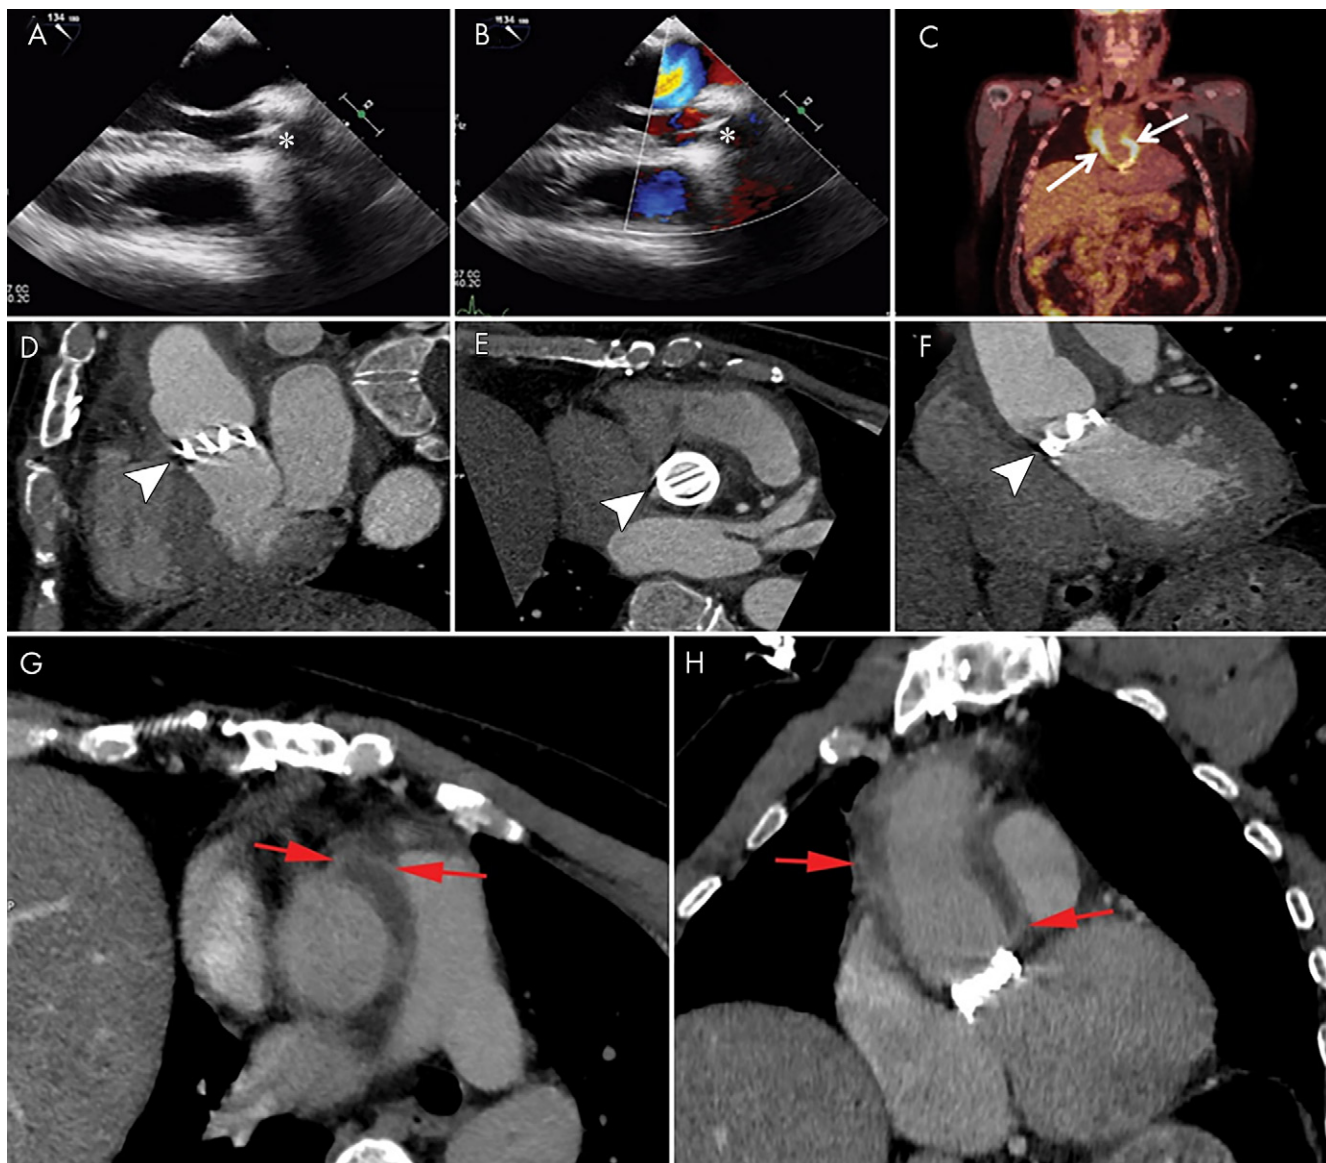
Images show a 48-year-old man with a history of Bentall surgery with placement of a mechanical valve 3 years prior to presentation with fever and positive blood cultures for *Staphylococcus aureus*. A, B, Transesophageal echocardiography images show a normal appearance of the mechanical valve (*) with no signs of endocarditis. C, Fluorine 18 fluorodeoxyglucose (^{18}F -FDG) PET/CT image shows intense ^{18}F -FDG uptake around the aortic prosthesis (arrows). D–F, Contrast-enhanced CT images show the mechanical valve (arrowheads) and, G, H, fluid collection with enhancing rim surrounding the aortic graft compatible with abscess (red arrows).
